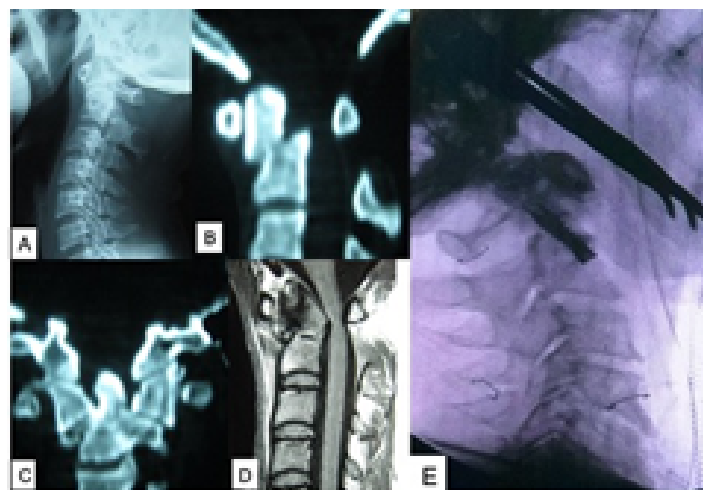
(A) X-ray of CVJ showing odontoid fracture with AAD; (B,C) CT scan of CVJ showing type 2 unstable odontoid fracture. (D) MRI of CVJ showing cord compression with instability. (E) Intraoperative X-ray showing reduction of odontoid fracture with fixation. Source: Figure by authors.
